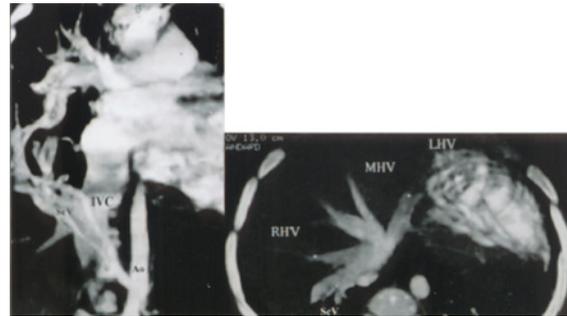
Three-dimensional imaging in the anteroposterior view, reconstructed from contrast-enhanced computed tomography clearly shows a scimitar vein connected to the inferior vena cava (IVC) (white arrows) Note an anomalous systemic artery from the abdominal aorta, which supplies the right lower lobe (black arrows).
